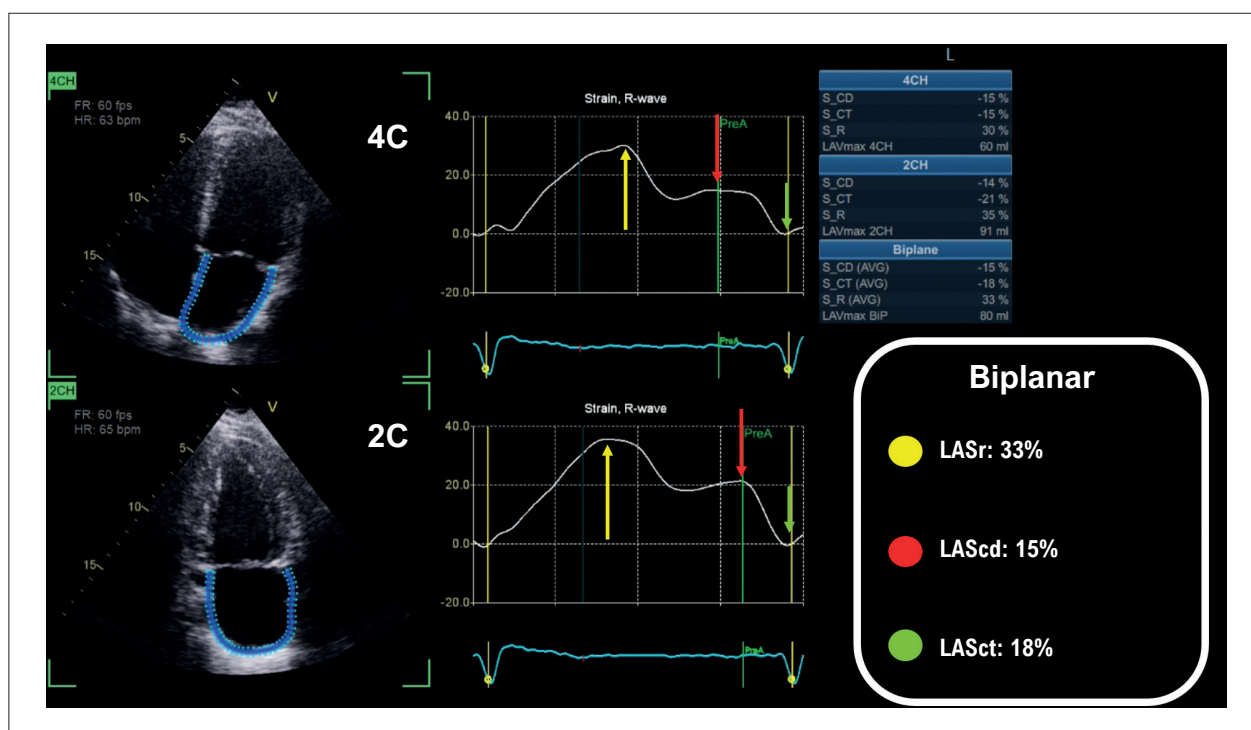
Analysis of left atrial strain in three phases (arrows: yellow = LASr; red = LAScd; green = LASct) in a patient with hypertension. Analysis was performed using dedicated software to measure left atrial longitudinal strain using automated left atrial endocardial tracking in apical two- and four-chamber views, following the recommendations of the European Association of Cardiovascular Imaging/American Society of Echocardiography/Industry Task Force to standardize deformation imaging.¹³ 2C: two-chamber view; 4C: four-chamber view; LA: left atrium; LAScd: left atrial conduit strain; LASct: left atrial contraction strain; LASr: left atrial reservoir strain.
